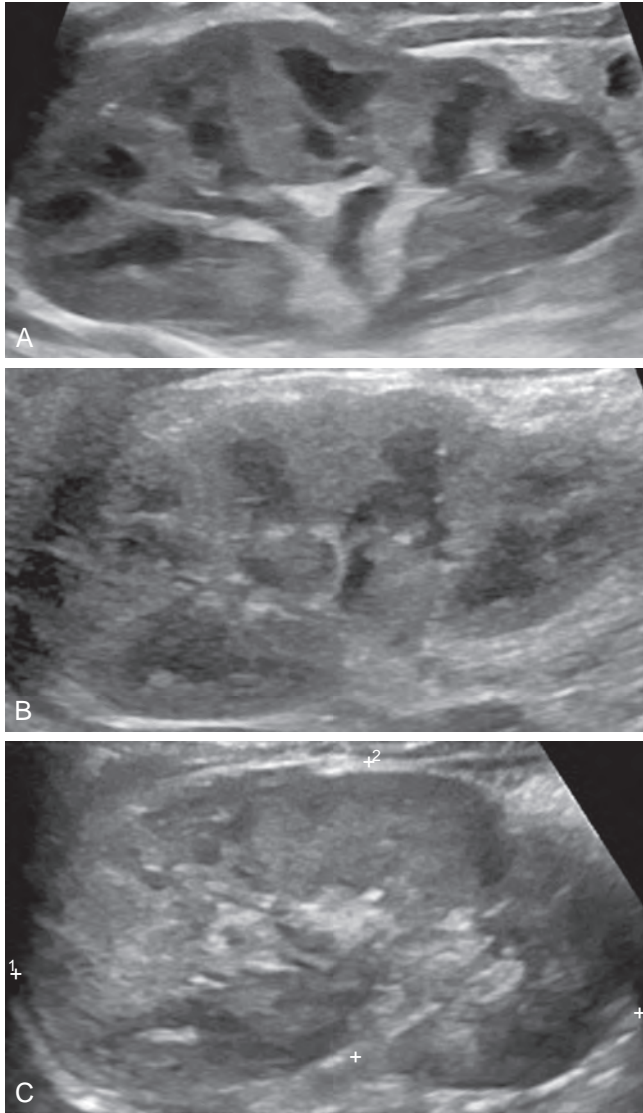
A and B, Postnatal sonograms demonstrating the high-contrast corticomedullary differentiation typical of the newborn kidney, which might be mistaken for dilated calyces. C, Renal sonogram in an older child for comparison.
